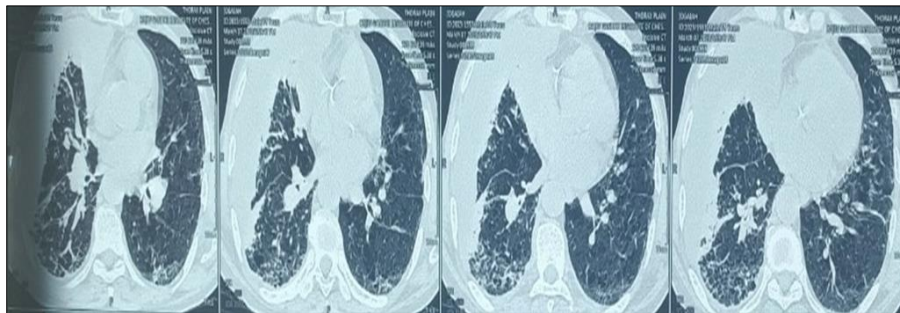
Computed tomography images showing chronic emphysema
